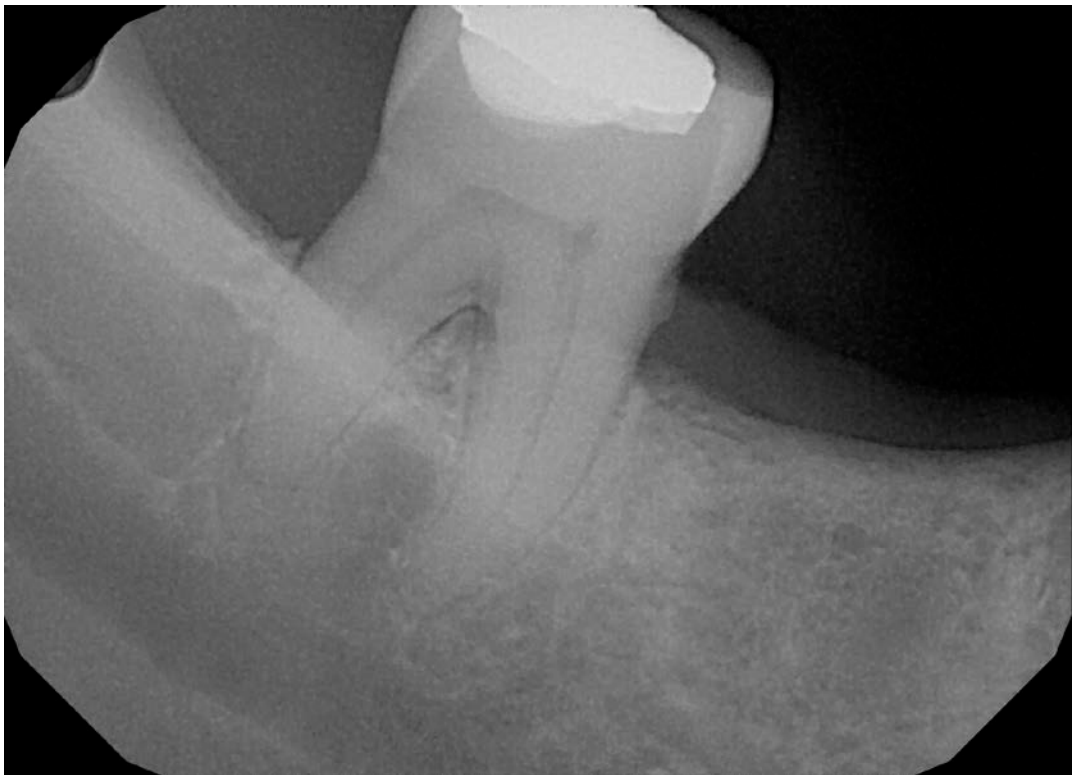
5-month postoperative Xray #31 showing complete radiographic healing
